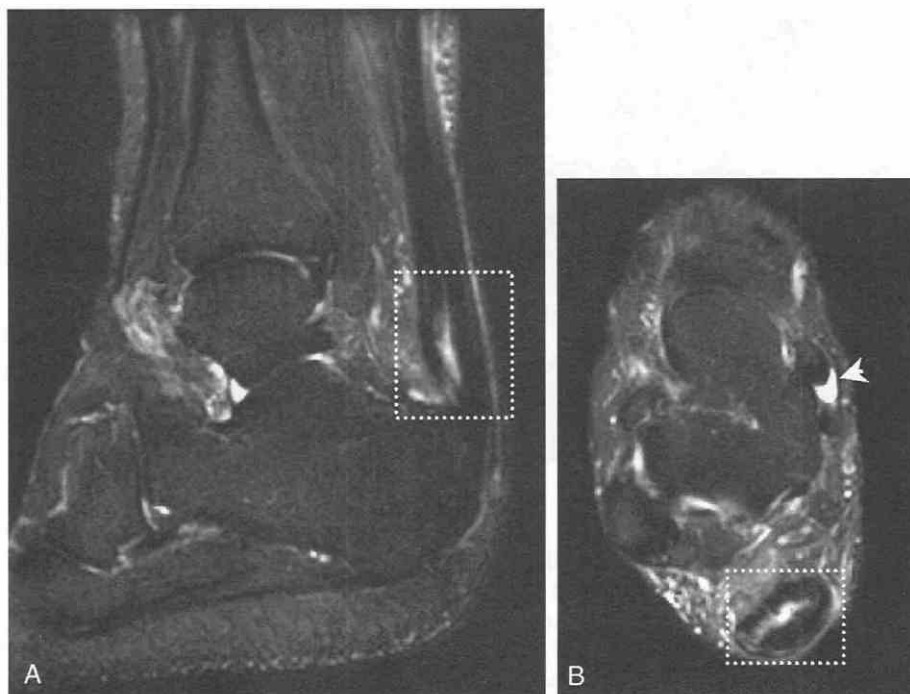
The patient is a 54-year-old woman with a history of rheumatoid arthritis and several months of persistent heel pain. Fat-suppressed T2-weighted images in the sagittal (A) and axial (B) planes reveal a type I partial intrasubstance tear of the Achilles tendon (*dotted rectangle*). An incidental finding is an abnormal amount of fluid in the posterior tibial tendon sheath (*arrowhead*).
